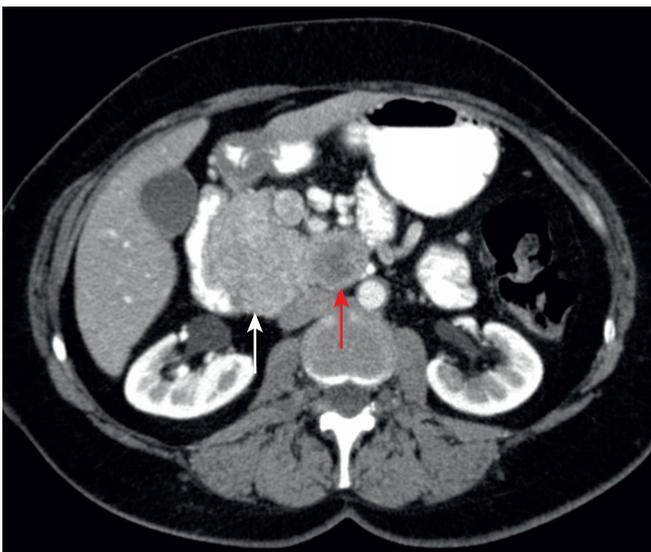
Arterial phase of a contrast-enhanced computed tomography of the abdomen showing an early enhancing pancreatic neuroendocrine tumor in the head and uncinate process of the pancreas (white arrow), with a necrotic node medially (red arrow).
